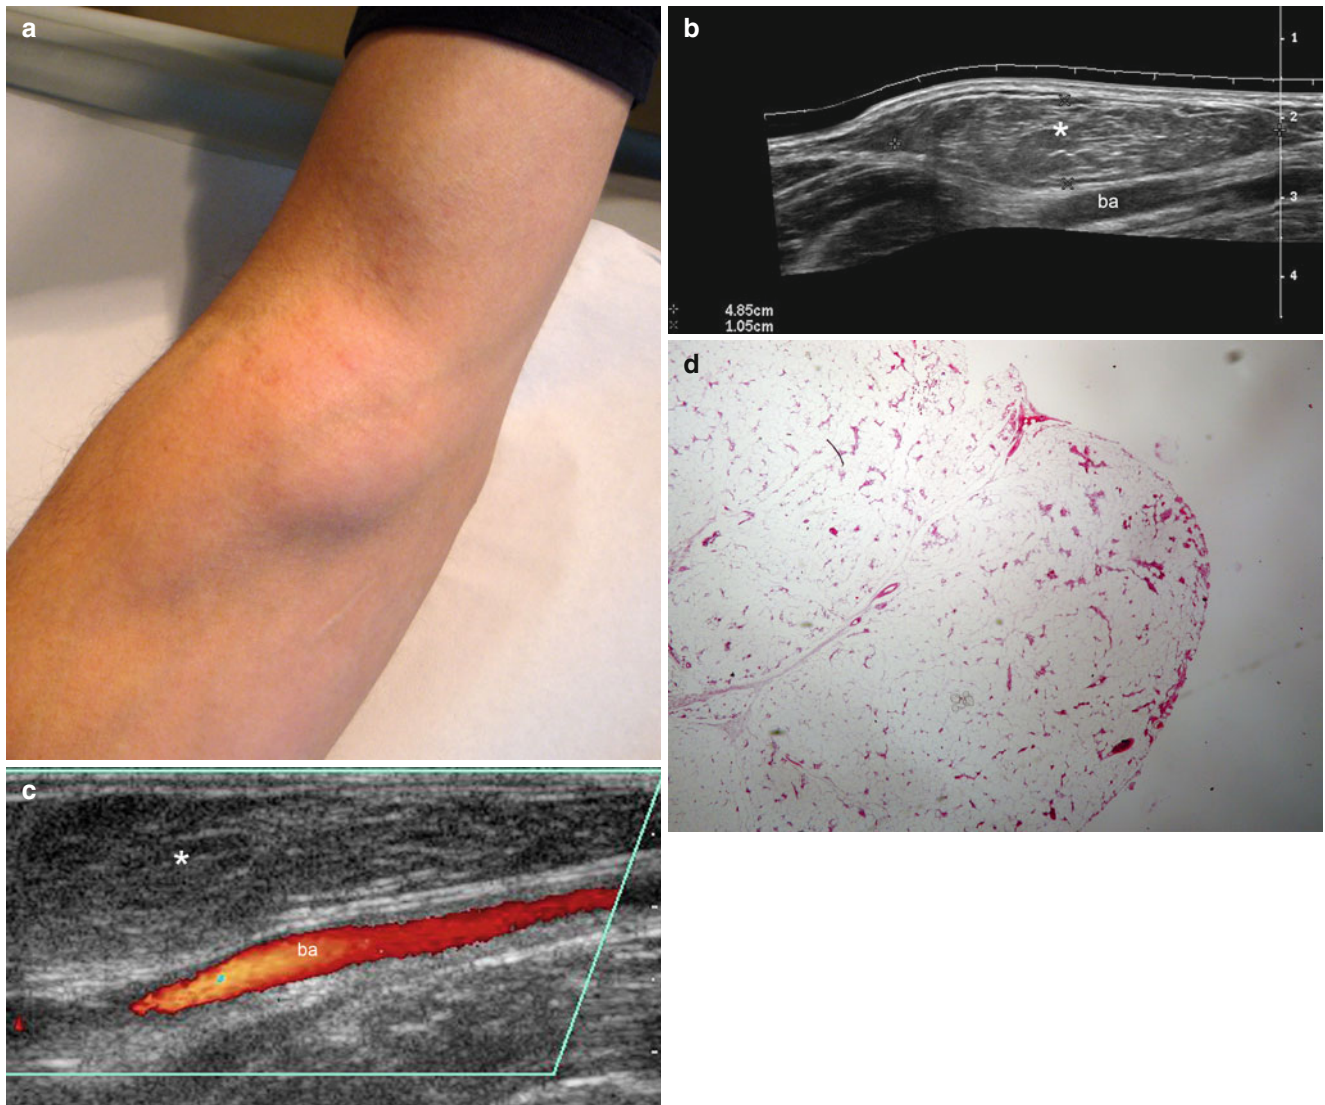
(a–d) Lipoma. (a) Clinical image shows skin-colored swelling in the left forearm. (b) Grey scale ultrasound image (longitudinal view) demonstrates a 4.85×1.05 cm well-defined, oval-shaped, hypoechoic structure in the subcutaneous tissue. The brachial artery
